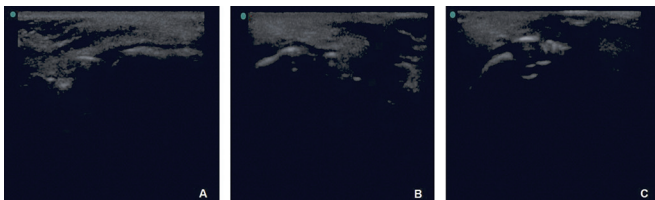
Tests ultrasound – typical homogeneous echogenicity in the anterior region of the left side, and labial one hypoechoic image, the longitudinal right to the orbicularis muscle of the lip (B and C) disagreeing with very image of a normal muscle of the mother (A).
